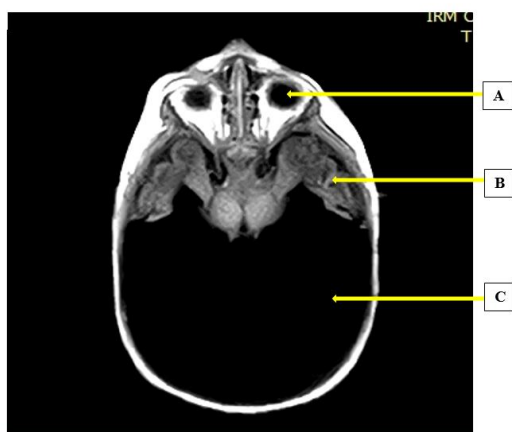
MRI scan of the encephalon in axial section displaying a single dilated supratentorial cavity pushing forward the remaining cerebral parenchyma. A= Left orbital cavity, B= Remaining cerebral parenchyma, C= Single dilated cavity
